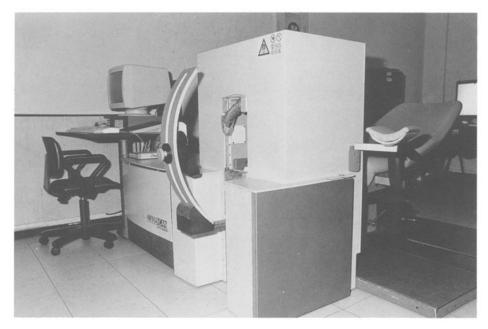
MRI dedicated unit: operator side.
